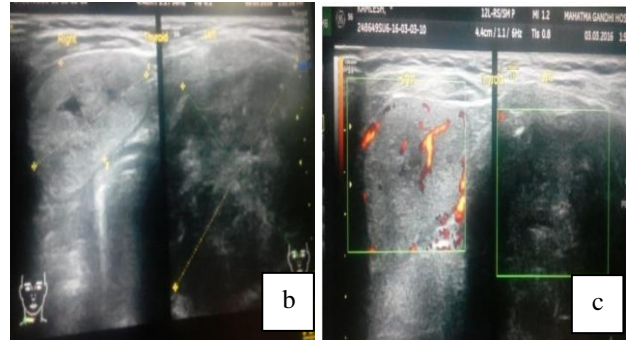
(b): Enlargement of right thyroid lobe; (c) on colour Doppler shows internal and peripheral vascularity.
